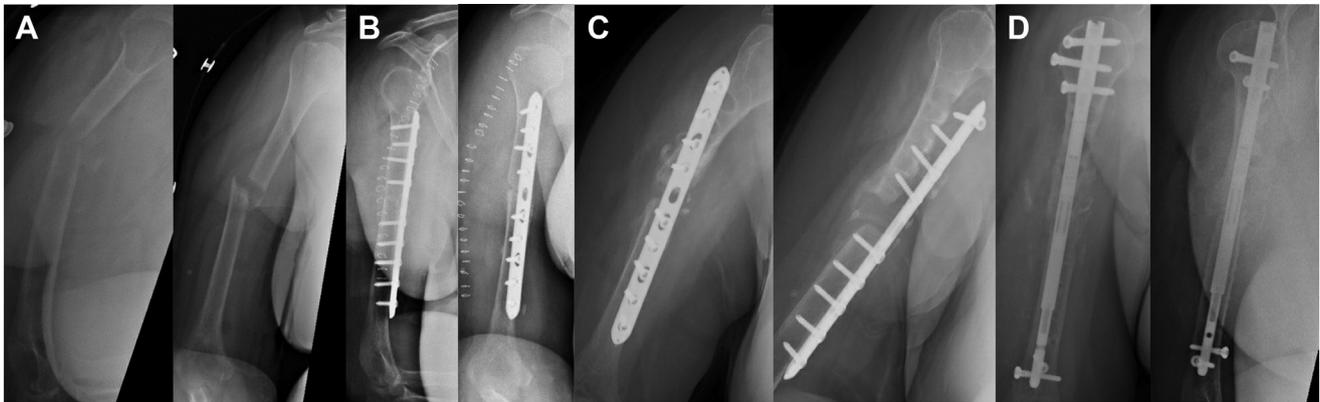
Radiographs of Humeral Nonunion Treatment Course. (A) Atrophic nonunion. (B) After open reduction internal fixation and grafting. (C) Failure of initial fixation. (D) Healing after magnetic intramedullary nail.
